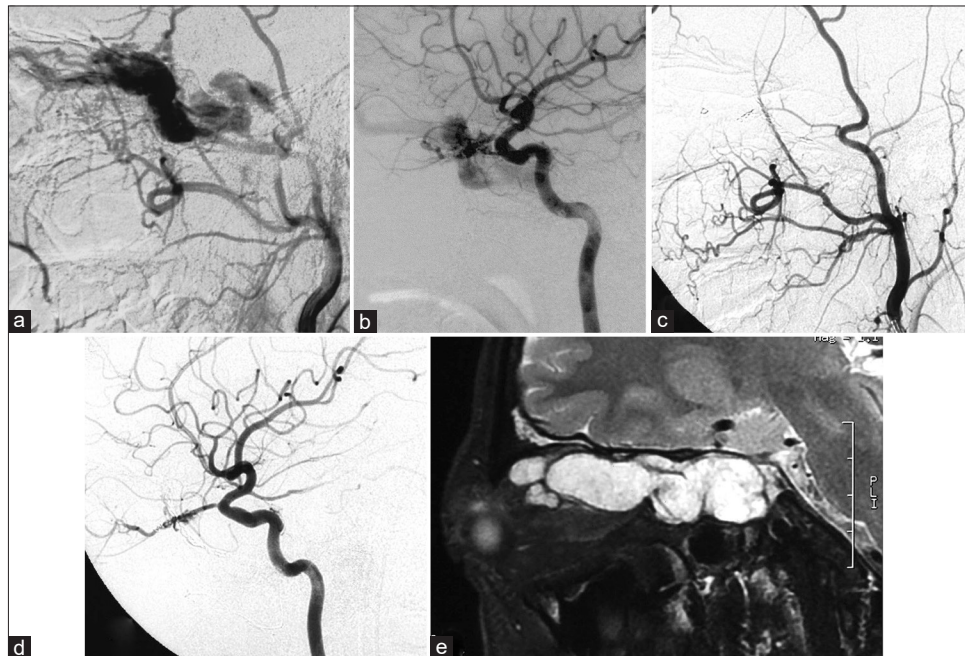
An 18-year-old man underwent embolization of a cavernous sinus. The external (a) and internal (b) carotid artery angiograms showing a dural AVF with multiple arterial feeders from the right middle meningeal artery, as well as a smaller contribution from the right ophthalmic artery. 3 years after the second treatment, the external (c) and internal (d) carotid artery angiograms demonstrating a residual dural fistula with a smaller contribution from the right ophthalmic artery. MRI (e) revealed prominence of the right superior ophthalmic vein
